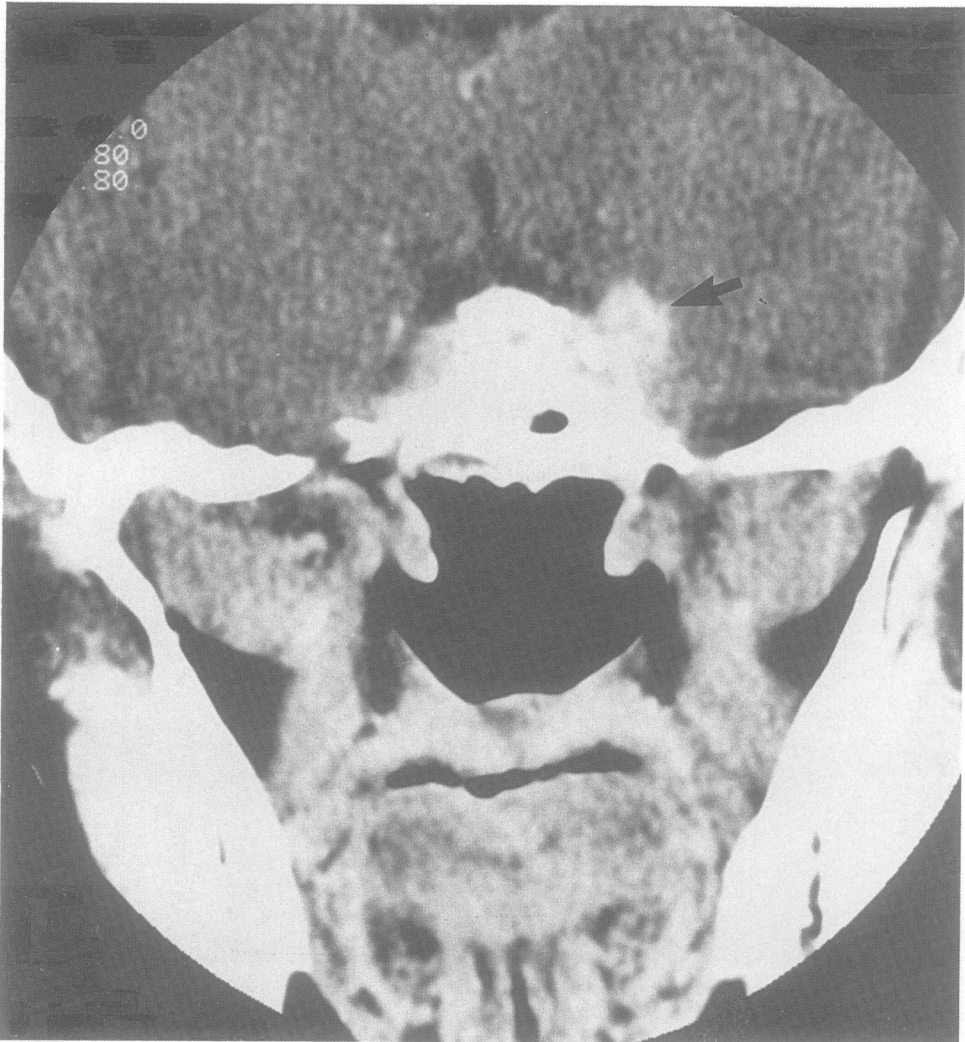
A cerebral CT scan with intravenous contrast showing a coronal slice through the anterior cranial fossa. A contrast-enhancing lesion is again demonstrated near the medial wall of the cavernous sinus.
